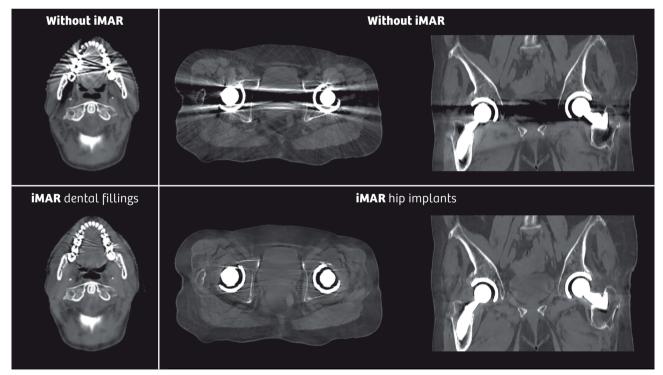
Influence of metal artifact reduction with iMAR for a head and neck patient (left) and a patient with hip implants on both sides (right). The same window level was used with and without iMAR. All CT images are reconstructed from a DECT scan as a pseudo-monoenergetic CT at 170 keV using MonoenergeticPlus, using the *syngo*.via application *syngo*.CT DE MonoenergeticPlus.
